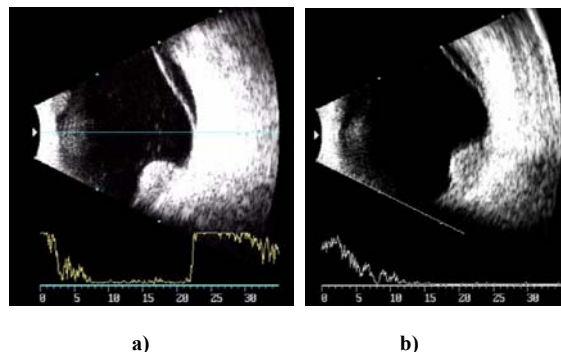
B-scan image of tumour ultrasonic investigations before (a) and after (b) brachytherapy
